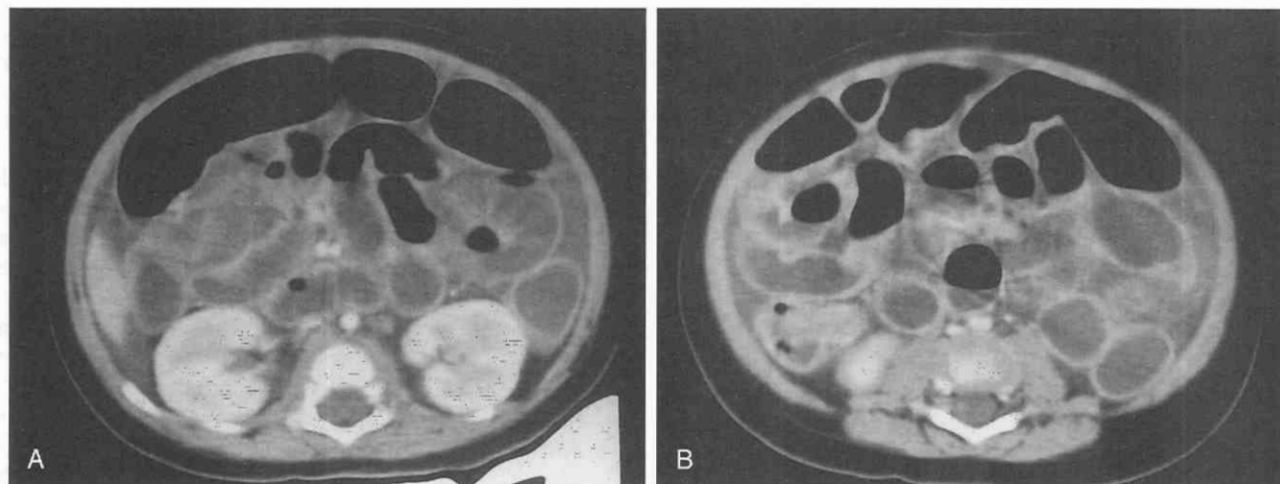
Hypoperfusion complex. CT scans through the upper abdomen (*A*) and the midabdomen (*B*) in a patient following blunt trauma demonstrate diffuse intestinal dilatation with fluid; intense contrast enhancement of bowel wall, kidneys, and great vessels; and diminished caliber of great vessels, consistent with the hypoperfusion complex.
